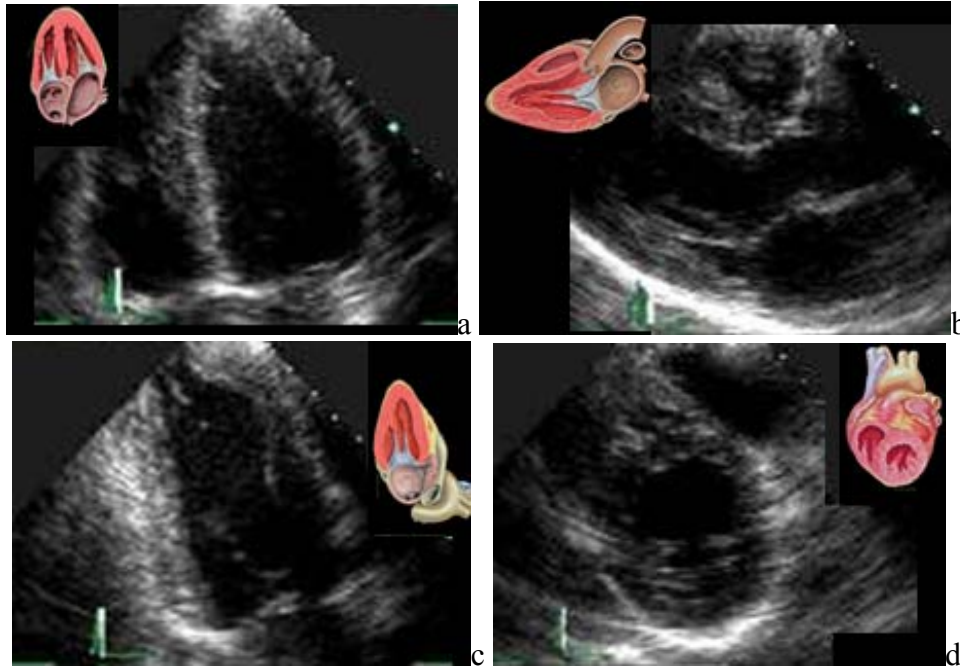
Different views of the heart. a) the four chamber view, b) parasternal long axis view, c) the two chamber view and d) the parasternal short axis view.
